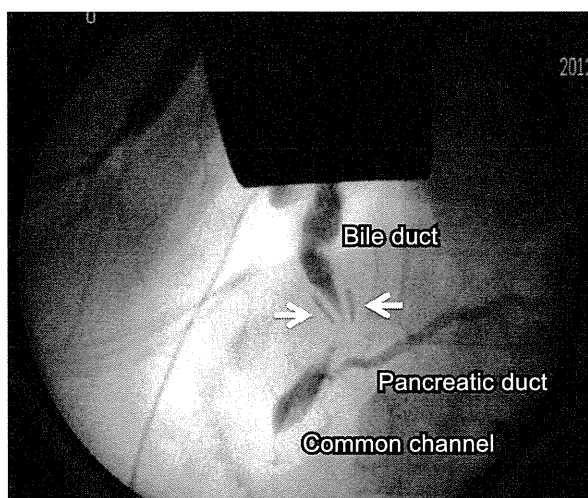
Radiographic examination with radiopaque clips (arrows). Radiographic examinations with radiopaque clips are helpful for determining proximity to the pancreaticobiliary junction.
